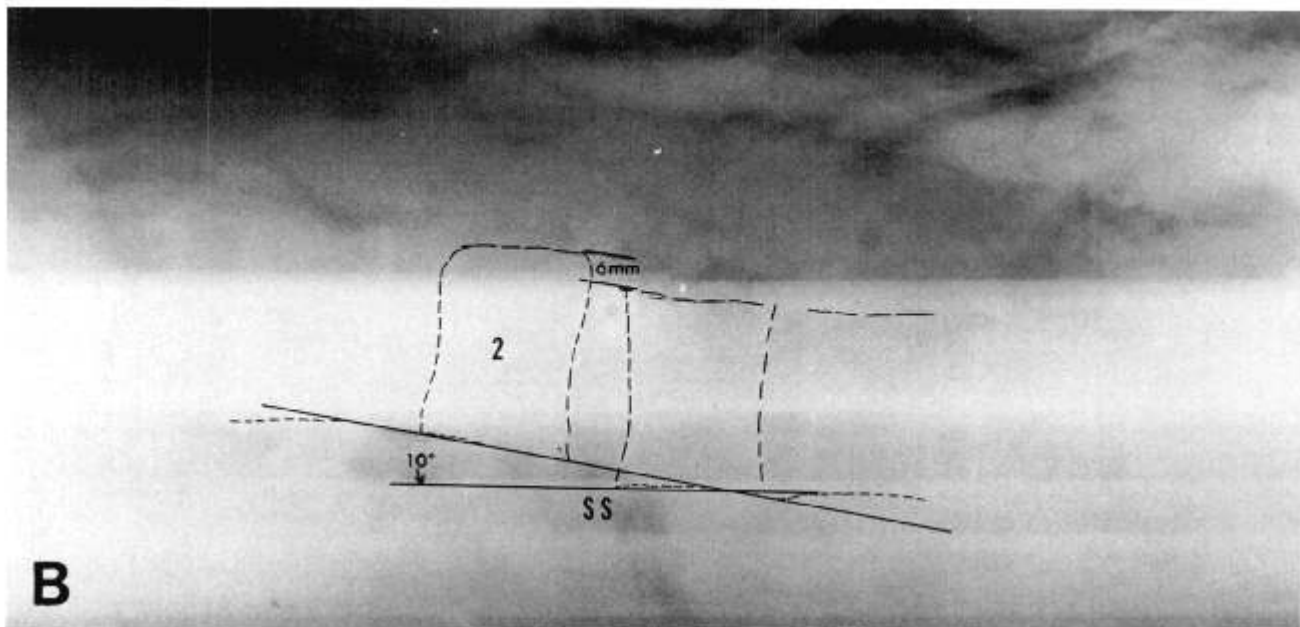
Lateral radiograph of the thoracolumbar spine on the scoop stretcher reveals an angular displacement of 10° at the unstable segment with an anteroposterior displacement of 6 mm.
